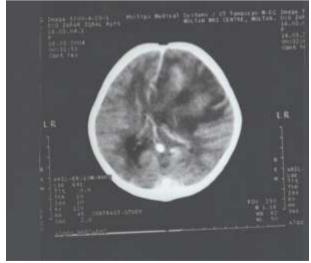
Contrast enhanced CT scan brain showing mixed density mass in left frontal lobe with mass effect. It shows patchy enhancement and extensive perifocal vasogenic oedema.
